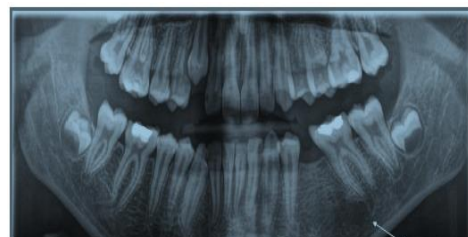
Control OPG X-ray showing good bone healing without relapse.
